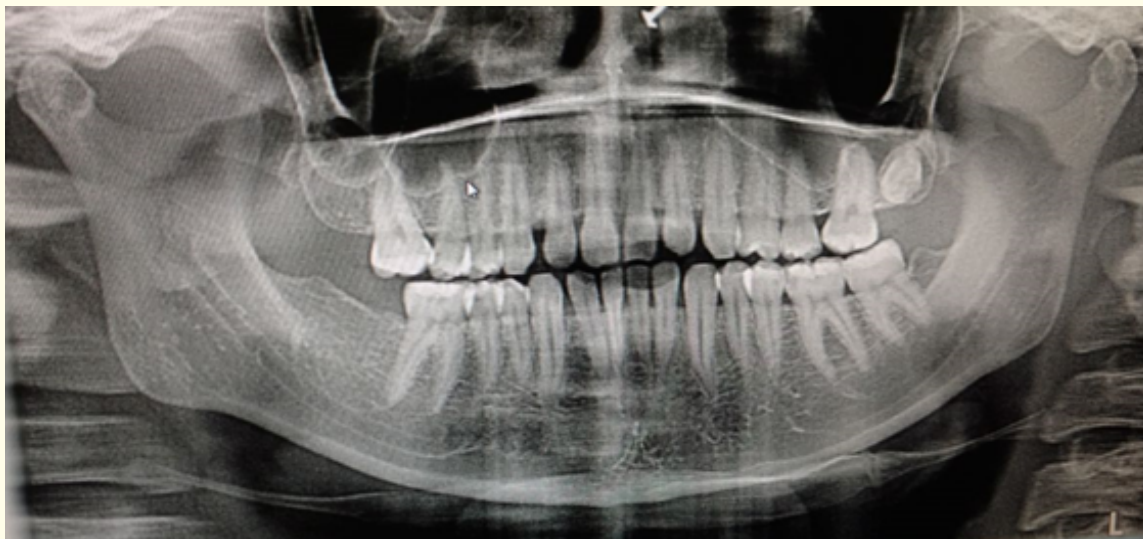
Orthopantomograph showing missing 47.
